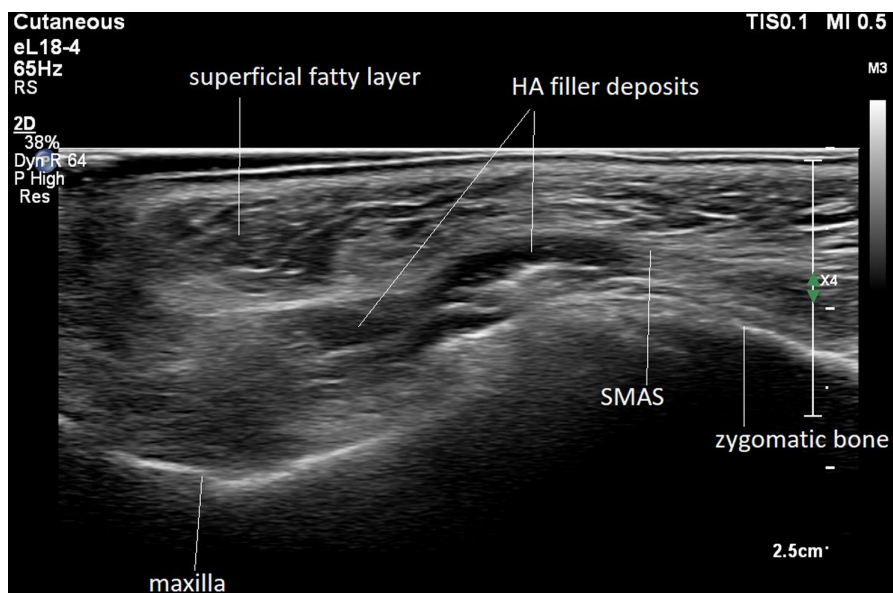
Ultrasound image showing the horizontal scan of the midface as indicated in the overview. The hyaluronic acid-based filler material is visible (HA) inside the fibrous layer closely related to the zygomaticus major muscle between the superficial and the deep fatty layers.
